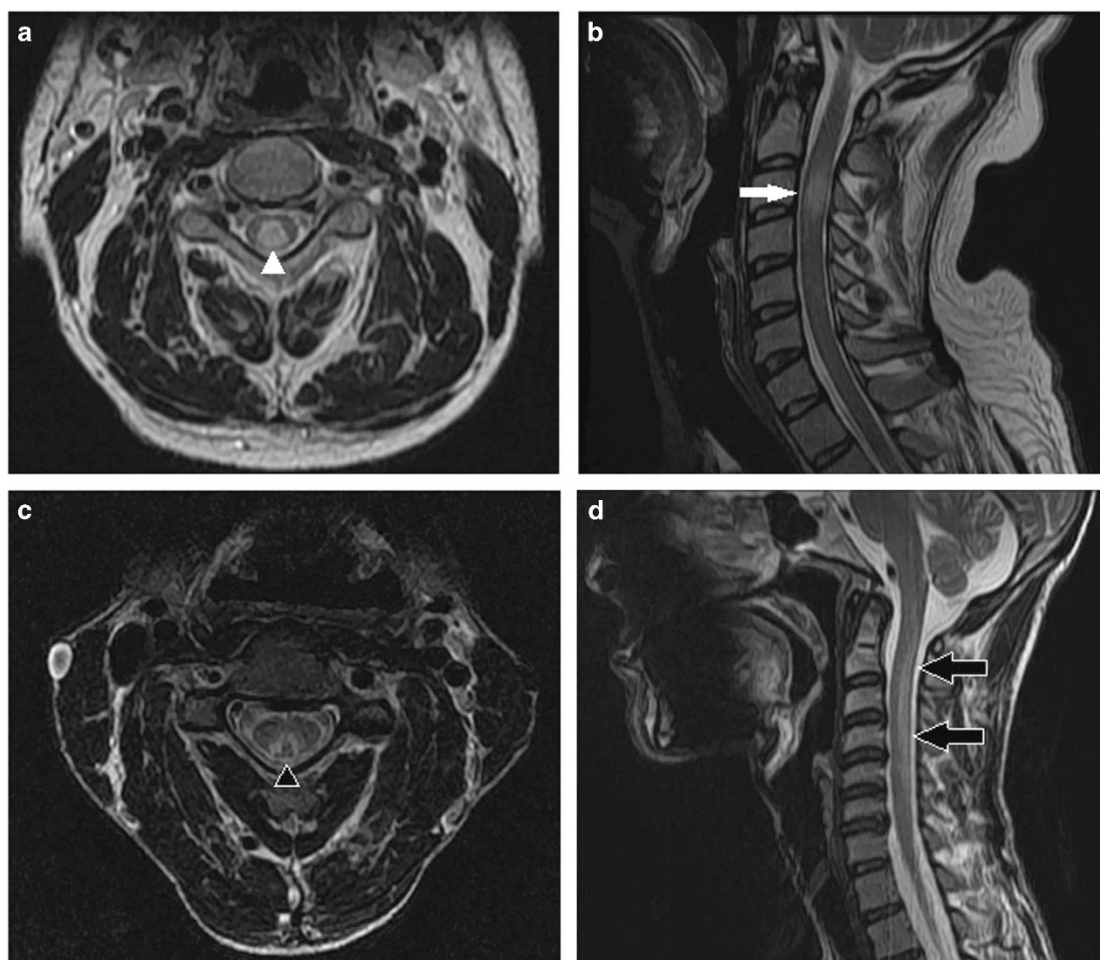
MRI of patient 1 showing posterior column hyperintensity (white arrow and arrowhead) of cervical spinal cord in T2 axial (a) and T2 midsagittal (b) sections. MRI of patient 4 showing classical 'V' sign (black arrowhead) in T2 axial image (c) with longitudinal posterior cervical spinal cord hyperintensity (black arrow) in T2 midsagittal sections (d).
